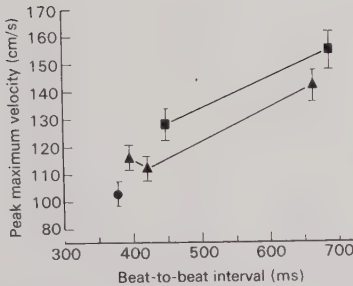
Ultrasonically measured peak maximum velocity of the fetal aortic blood flow related to the preceding beat-to-beat interval (patient no. 1, 36th week of pregnancy, mean $\pm$ SD). ●, Period of regular tachycardia; ■, period with beats grouped in pairs; ▲, period with beats coupled in groups of three.
